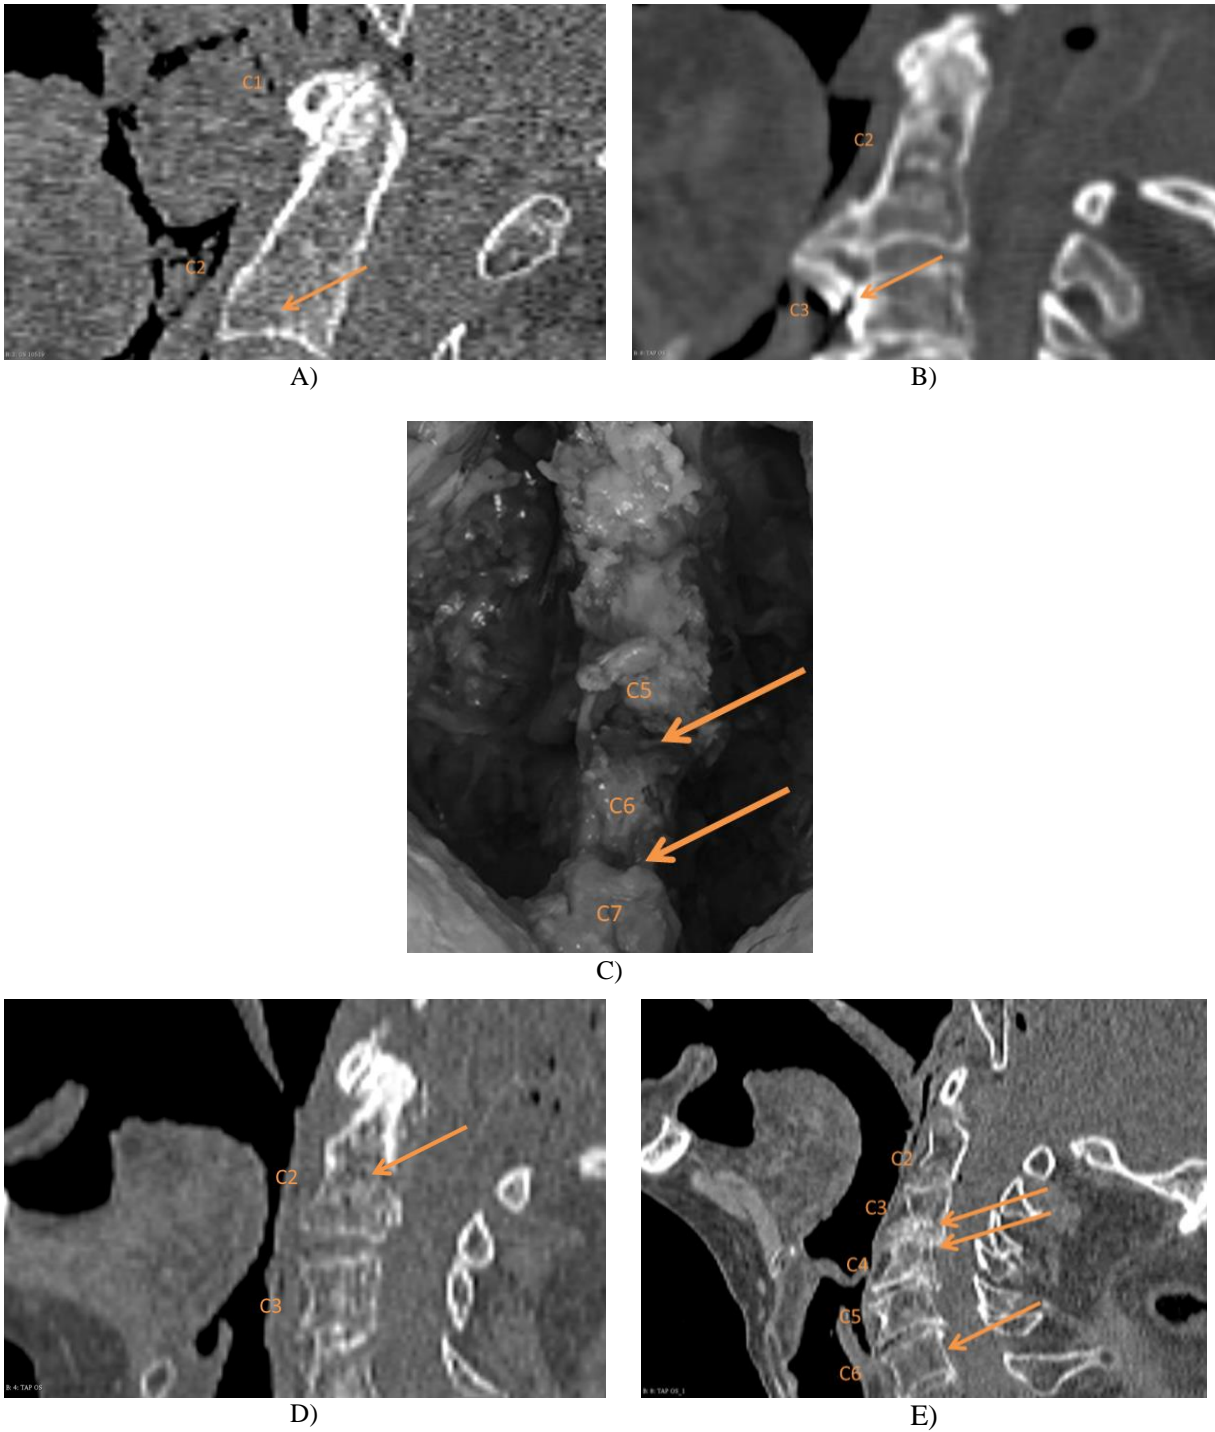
Post-impact injuries as seen on CT scan images. A) C2 endplate fracture shown on CT scan images (PMHS #1) B) Anterior osteophyte fracture at C3 shown on CT scan images (PMHS #2) C) Dissection of posterior cervical spine showing ligamentous disruption at C5-C6 and C6-C7 (PMHS #4) D) Odontoid fracture shown on CT scan images (PMHS #5) E) Vertebral body fracture at C3, C4 and C6 shown on CT scan images (PMHS #6)
